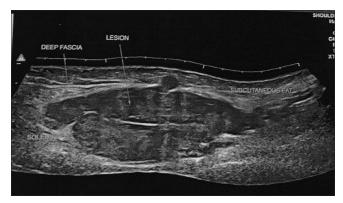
Ultrasound of the right calf showing hypoechoic lesion in soleus of approximate 4.4 cm \times 4.4 cm \times 10 cm
